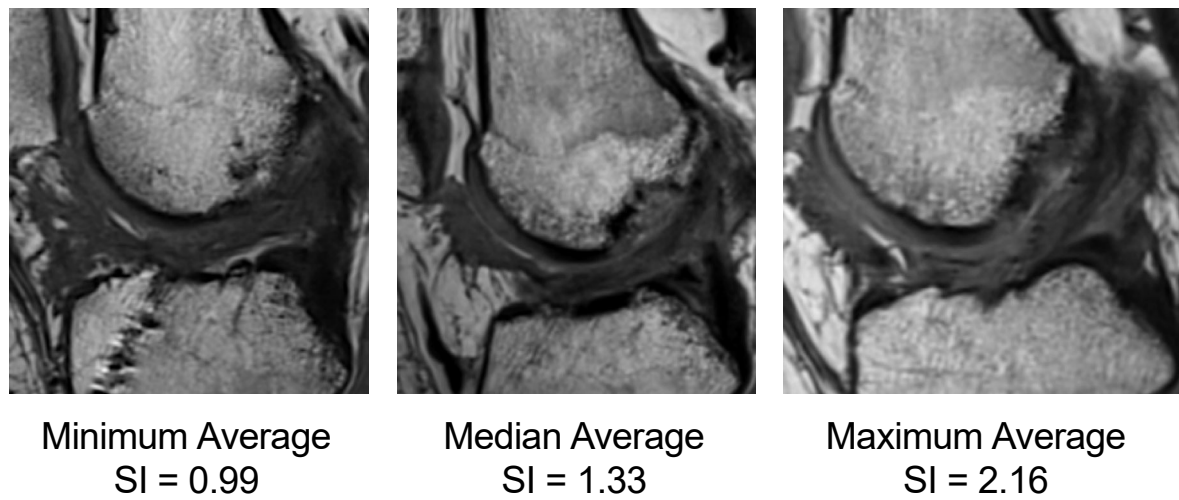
MR images of repaired ACLs with minimum, median and maximum normalized signal intensity 6 months after bridge-enhanced ACL repair.
